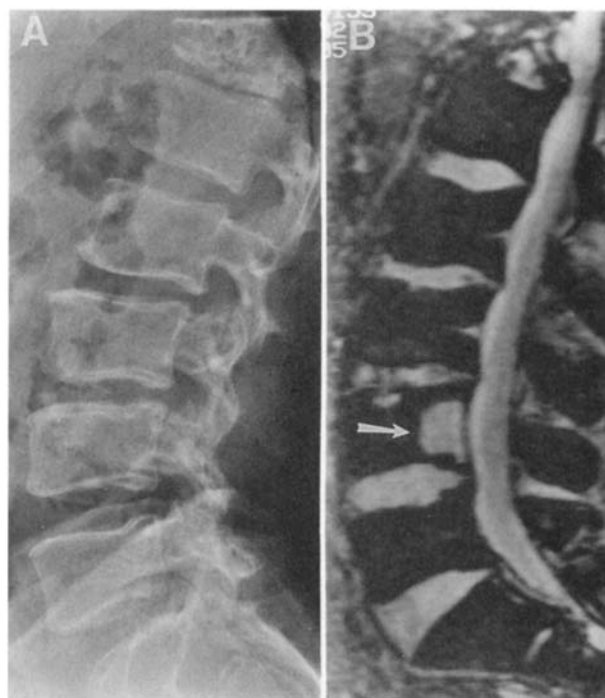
(A) Conventional radiograph of the lumbar spine shows pathologic compression fracture of the T-12 vertebra. (B) GRASS sagittal MR image (250/20; 20-degree flip angle) shows the involvement of the T-12 vertebra and an additional focus of disease at L-4 (arrow).
